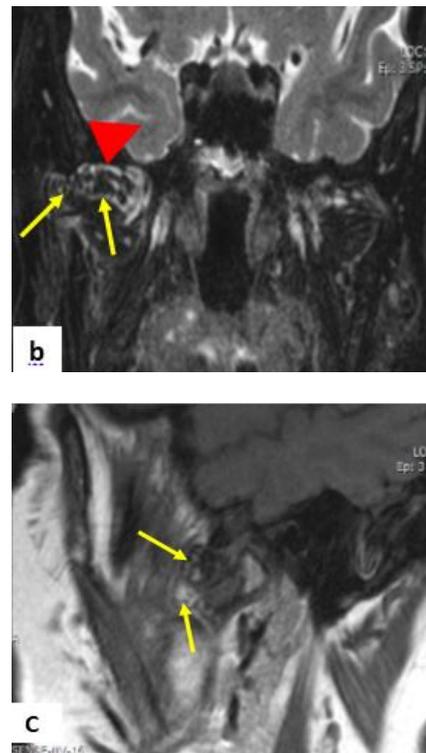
Axial T2-weighted (a) and coronal T2 STIR images (b) displays both the presence of low-signal intensity loose bodies (yellow arrows) and fluid effusion (arrowhead) in the right TMJ. Sagittal-oblique T1-weighted (c) image show loose bodies in high-signal intensity because they are ossified.
